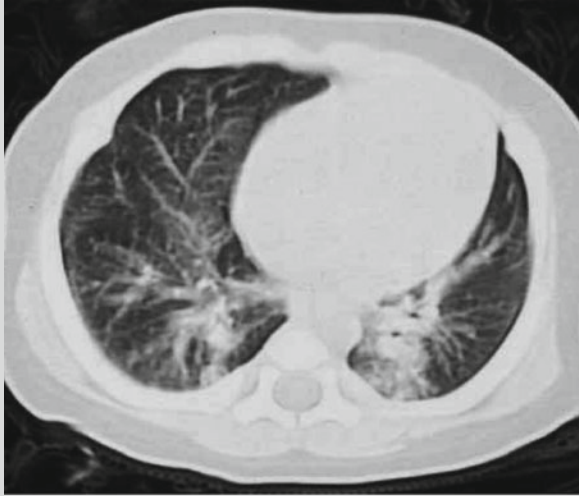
Pertussis complicated by pneumonia. CT scanning demonstrates thickened vascular bundle of bronchus of both lungs, with poorly defined boundaries and flakes of ground-glass opacities and patches of shadows (Reprint with permission from Abe and Watanabe *Pediatr Emerg Care*, 2003, 19(4): 262)
